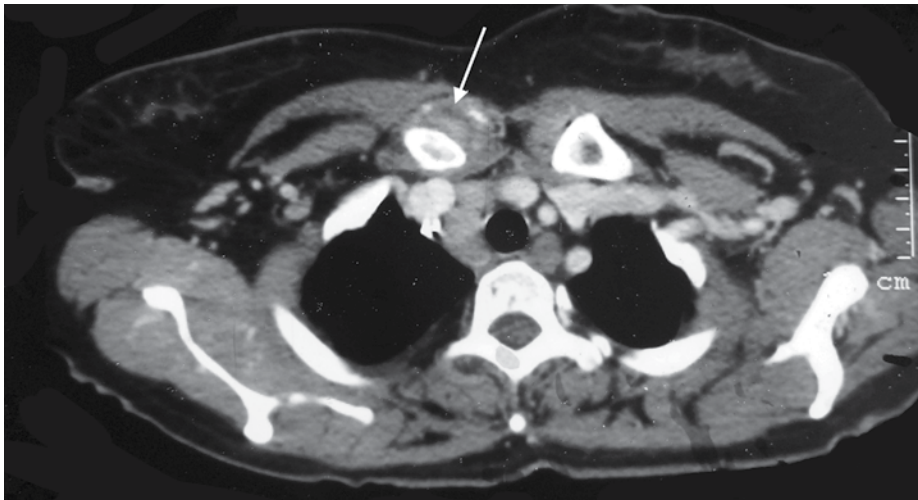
Axial contrast-enhanced CT of the thorax showing increased thickness of the soft tissue around the medial end of the right clavicle (arrow) compared with the left clavicle
